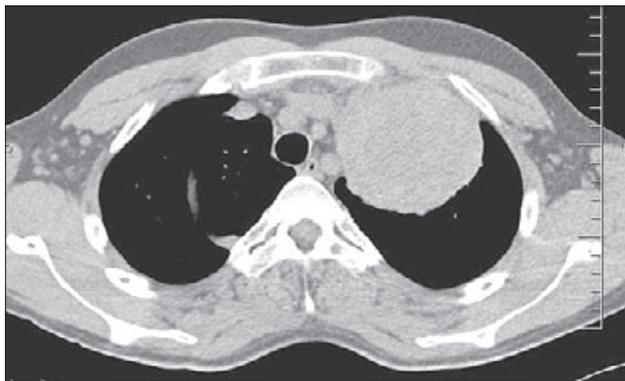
Chest CT scan-pulmonary metastatic lesion.
